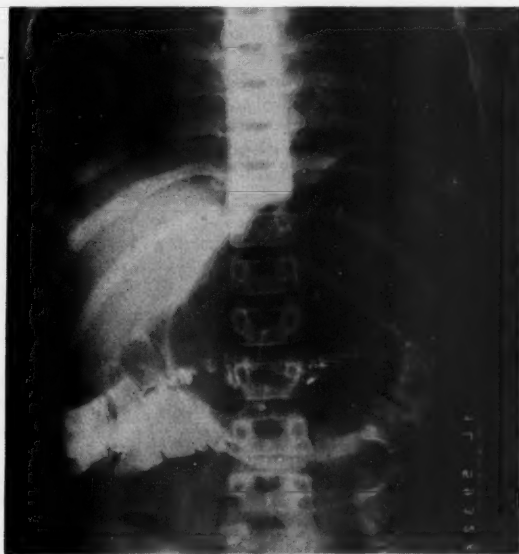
Photograph of preoperative roentgenogram of abdomen. Note the large rounded cystic mass (megaileum) in the upper left quadrant.
